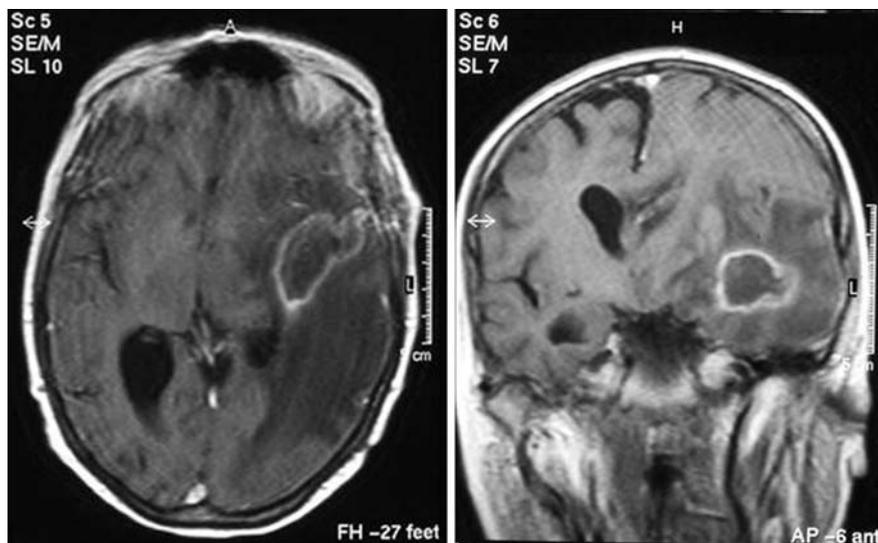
(A) and (B). *Aspergillus* cerebral abscess in a patient with post-operative neurosurgical infection (T1 weighted, gadolinium enhanced magnetic resonance imaging)
